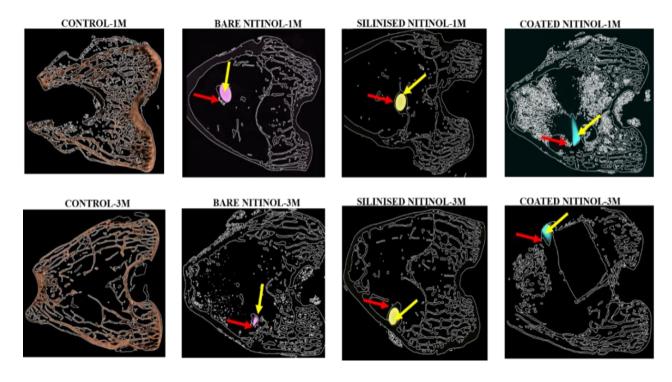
Radiographic 2D images of defect bone sites showing extent of healing after 1month and 3 month (Red arrow showing new bone growth around the implant; yellow arrow showing implant material)
